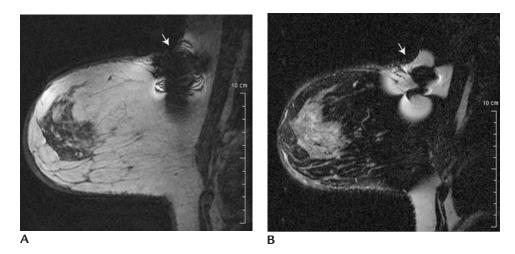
Artifact from portable catheter. (A) Sagittal T1-weighted image and (B) Sagittal, fat suppressed T2-weighted image. Significant "bloom" artifact with loss of signal noted at the site of a portable catheter used for chemotherapy administration.
